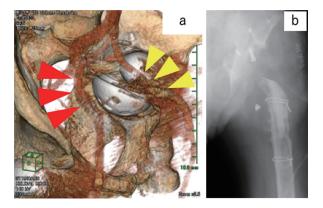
Case 2. a. Anteromedial view of the left pelvis in 3D CT angiography. The external iliac artery (yellow arrowhead) was displaced by the protruded head, and the internal iliac artery (red arrowhead) was close to the migrated cup. b. Postoperative anteroposterior left hip radiographs.
